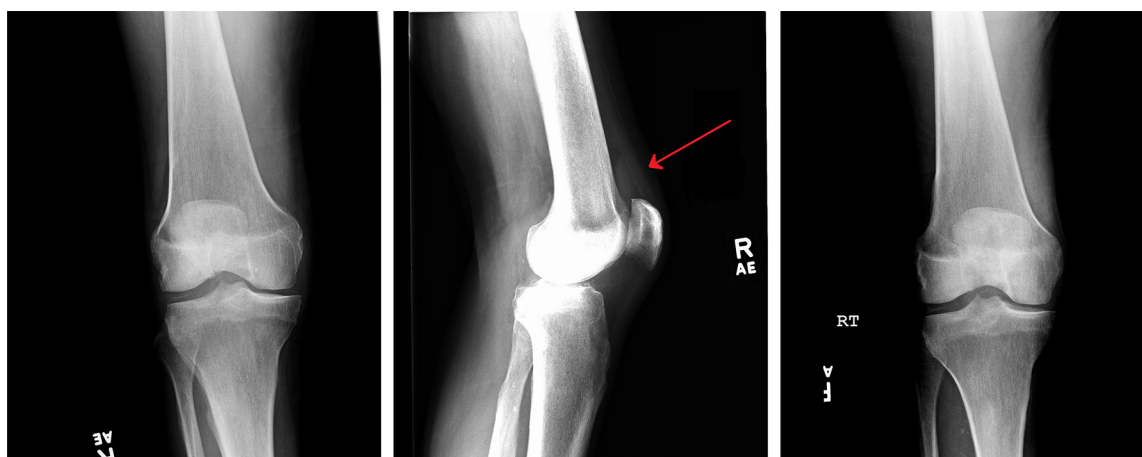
Three-view radiographs of the right knee demonstrate mild joint space narrowing of the medial tibiofemoral compartment and capsular distension.
